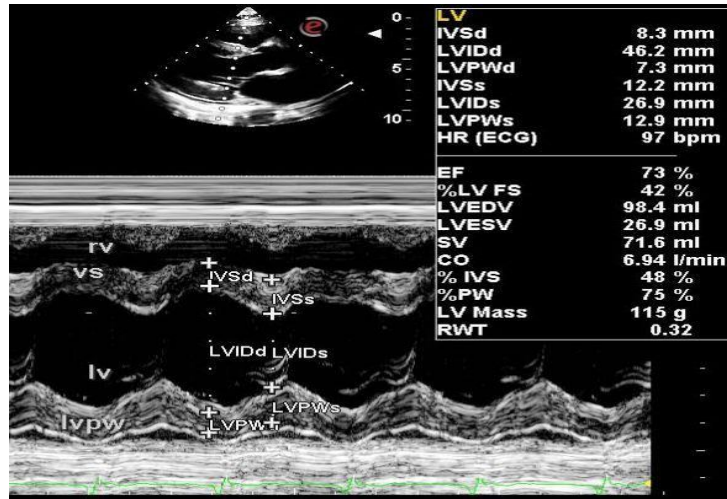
M-mode echocardiography of LV.
